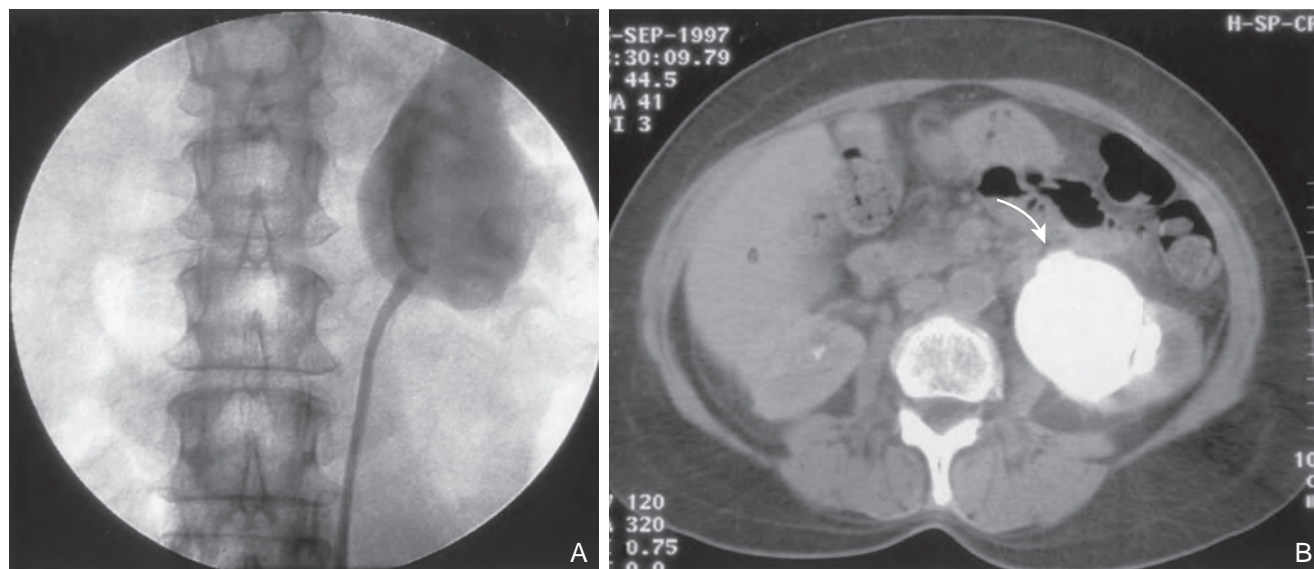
A, Retrograde study in this patient with left ureteropelvic junction obstruction reveals a “high insertion” of the left ureter. B, Computed tomography scan in the same patient reveals the ureter inserting on the anatomically anterior aspect of the renal pelvis. A marsupializing incision must be made in a true posterior direction from the ureter into the renal pelvis.
